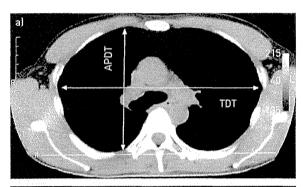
Chest computed tomography scan from a 55-year-old male with pleuroparenchymal fibroelastosis (case 2) at the level of the 6th thoracic vertebra a) on admission and b) 5.27 years later. The anteroposterior diameter of the thoracic cage (APDT)/transverse diameter of the thoracic cage (TDT) ratio decreased after 5.27 years. Note the space present between the anterior edge of the ascending aorta and the anterior chest wall in (a). The anterior edge of the ascending aorta was attached to the anterior chest wall after 5.27 years. TDT was determined as the longest transverse diameter of the thoracic cage measured parallel to a line (#) that runs along the rearmost points of the bilateral 6th ribs in the horizontal section of the CT.
